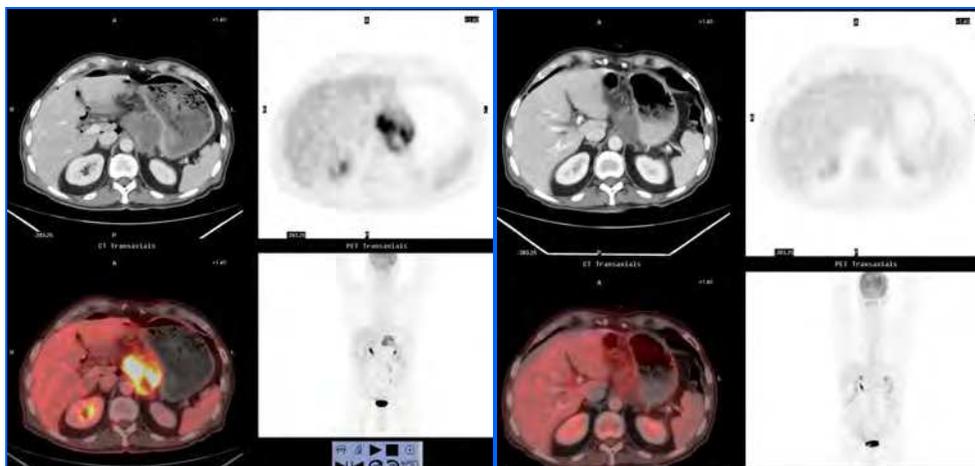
45-year old patient with Diffuse large B-cell NHL with a mass that shows an intense FDG avidity at diagnosis (a). The mass persists after the end of the treatment, without FDG uptake. The recurrence was confirmed with monitoring, without additional treatment (b).
